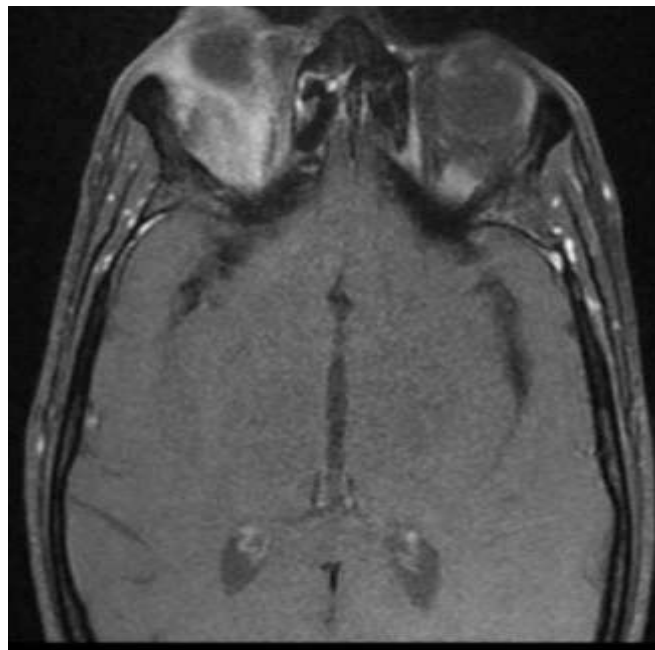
Orbital MRI, axial section, showing a right extra conical process suggesting a lymphoma or an inflammatory pseudo tumor.
